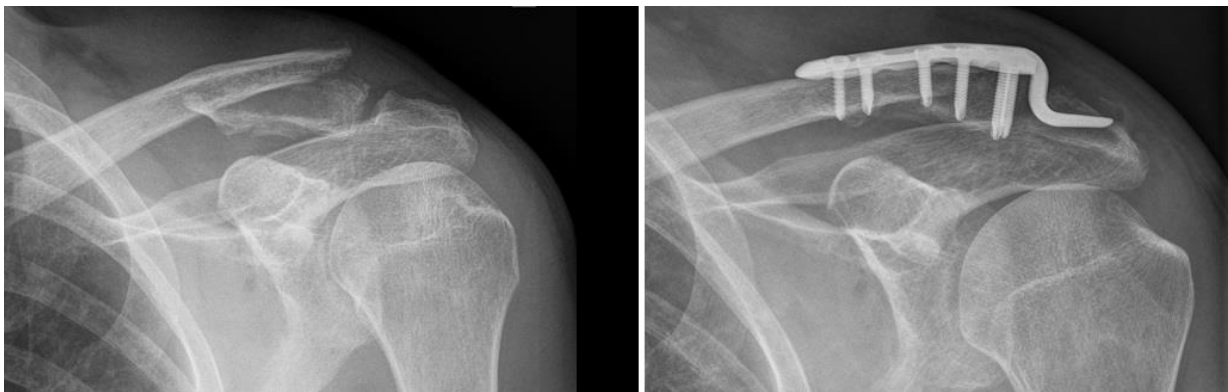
Preoperative radiograph of LCF and postoperative radiograph after CHP fixation.
